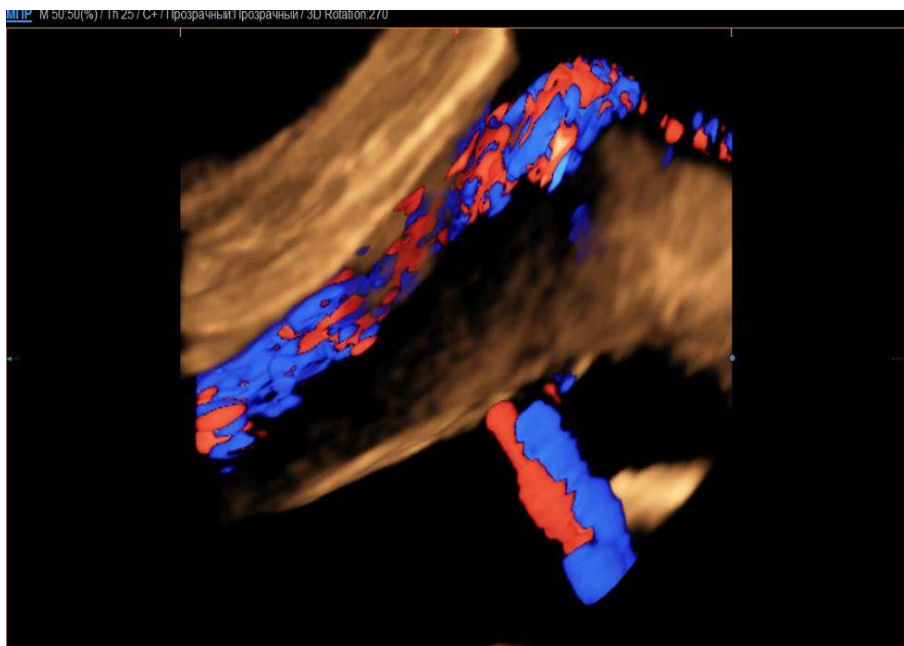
Color dopplerography. Complete remodeling of spiral arteries with normal indicators of blood flow resistance in the AI pregnant group.
